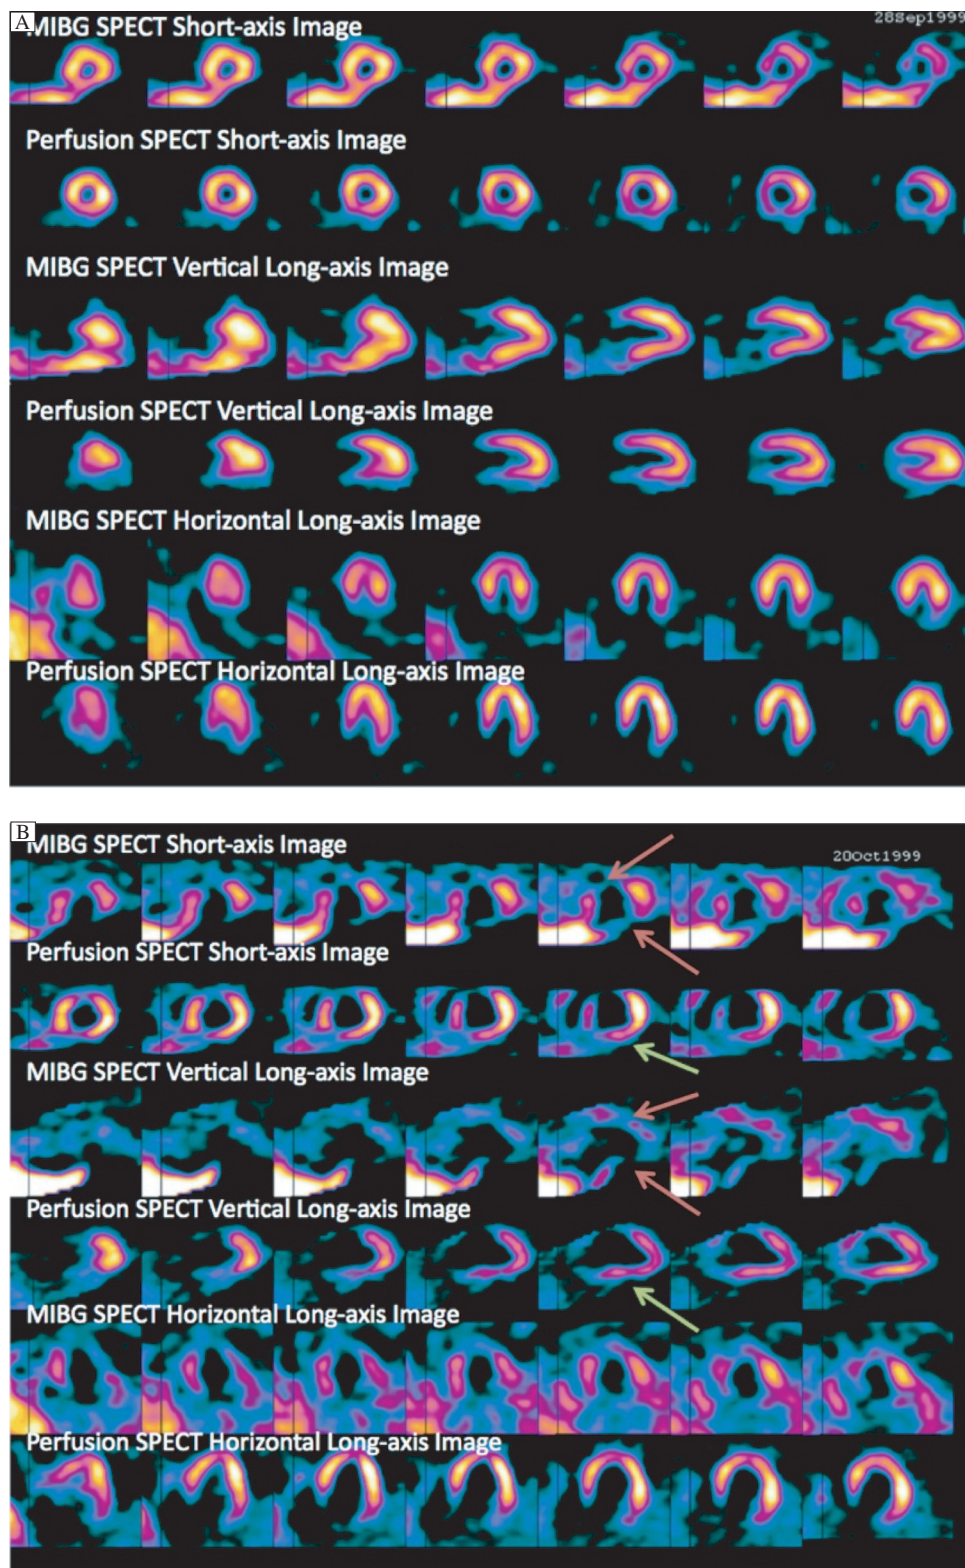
MIBG and perfusion SPECT images of two HF patients with ICD. (Courtesy of Mark I. Travin, MD, Montefiore Medical Center, Bronx, NY, USA). A: A representative HF patient with ICD, but not experiencing ICD shocks. Both MIBG and perfusion SPECT images show good myocardial uptakes of the MIBG and perfusion tracers, respectively, indicating a low risk of ventricular arrhythmia in this patient. B: A representative HF patient with ICD, and experiencing ICD shocks. The MIBG SPECT images show low myocardial uptakes of MIBG in the anterior and inferior wall (red arrows). Good myocardial perfusion is observed in the inferior wall as shown by the perfusion SPECT images (green arrows). Therefore, this patient has large MIBG defects in both anterior and inferior walls and prominent MIBG/perfusion mismatch in the inferior wall, indicating a high risk of ventricular arrhythmia.
